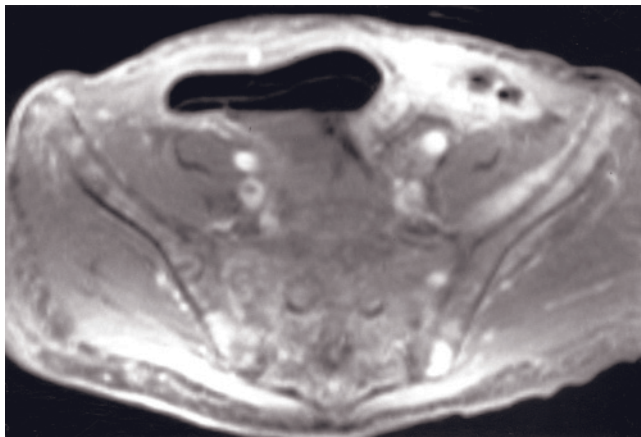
Bladder invasion by malignant disease. Sagittal T2-weighted single-shot echo-train spin-echo (a), sagittal
